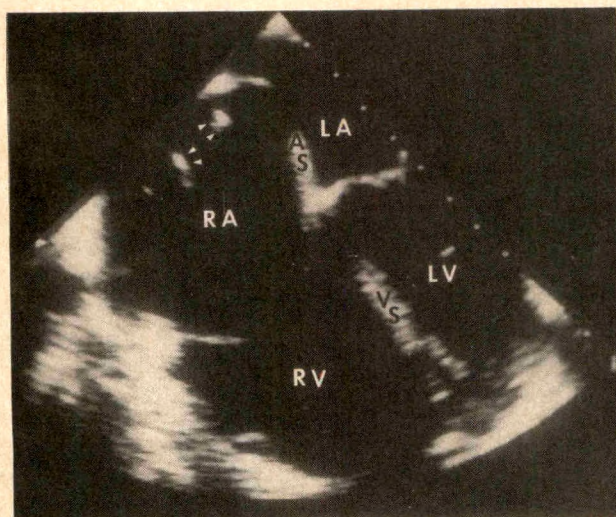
Left, transesophageal 4-chamber view, demonstrating right ventricular (RV) infarct. Right cardiac chambers are dilated and atrial septum (AS) bulges toward left atrium (LA) because of high right atrial (RA) pressure. Swan-Ganz catheter and temporary pacemaker wires are seen in right atrium (arrowheads). Right, because of persistent hypoxemia despite oxygen therapy, right-to-left shunt was suspected. Contrast agent injected into the right atrium appears immediately in the left cardiac chambers, confirming right-to-left shunt across a patent foramen ovale. LV = left ventricle; VS = ventricular septum.
